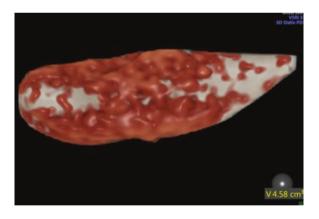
3D ultrasound acquired and VOCAL calculated volume of endometrium
